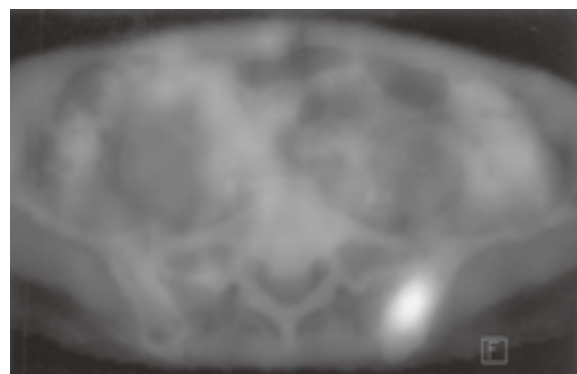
Case 3. PET/CT fusion image of a hypermetabolic metastasis in the left iliac bone in a 64-year-old man with papillary cell thyroid carcinoma. Several bony metastases involving the vertebrae and ribs are also present (not shown).
